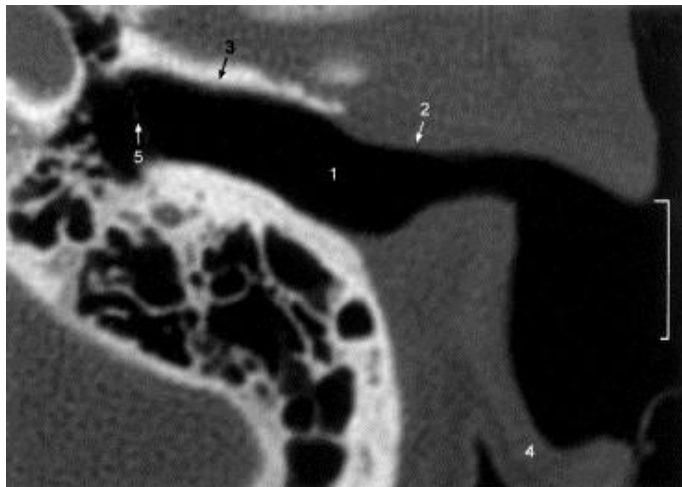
Axial CT image at the level of the left temporo mandibular joint.
